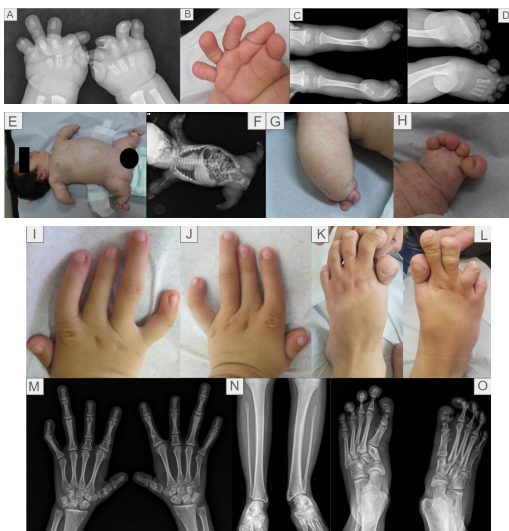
Case 2, radiographs of hand, showing bilateral absent fibula and type-C brachydactyly (A-D). Case 2, presenting severe acromesomelic and rhizomelic shortening, with absent ossification of long bones/phalanges, a globular appearance of the fingers (E-H). Case 2, type-C brachydactyly, bilateral fibular hypoplasia and postaxial polydactyly of the right foot (I-O).
